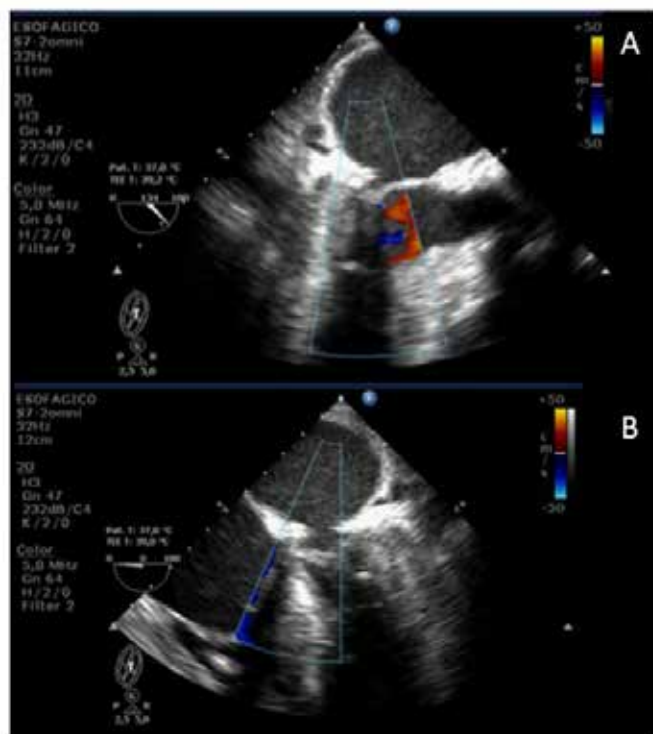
Transesophageal echocardiogram image after mitral valve repair. A. Middle esophageal long axis cut showing adequate mitral valve opening without regurgitation towards the left atrium. B. Mid-esophageal four-chamber view showing absence of mitral insufficiency.
